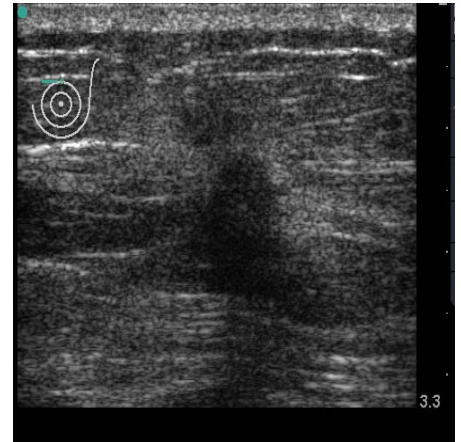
Ultrasound image of lesion
